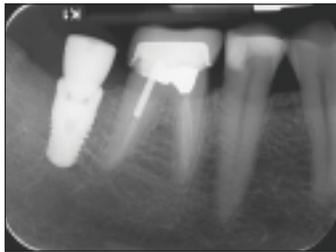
Postoperative periapical radiograph immediately after implant placement and abutment connection, position No. 31.
